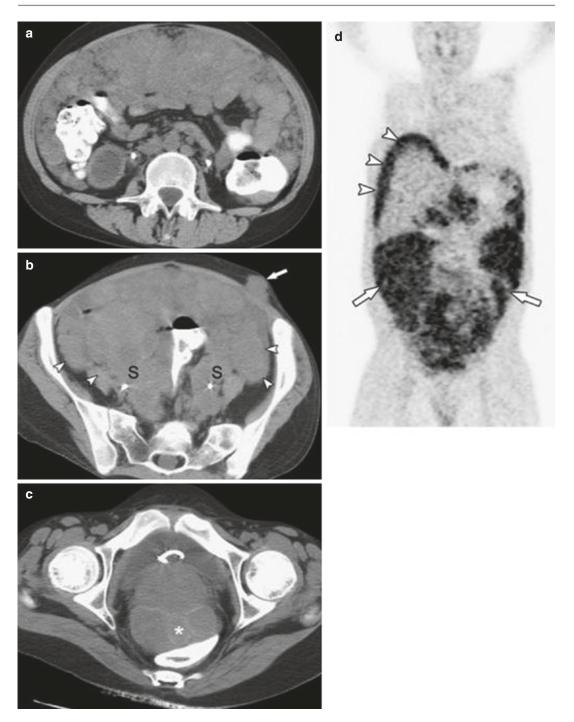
Desmoplastic round cell tumor in a 14-yearold boy. Axial (unenhanced) CT image (a) shows diffuse studding of the omentum and peritoneal surfaces by innumerable soft tissue masses. Axial image through the pelvis shows lobulated low attenuation masses (*arrow heads*) and a large retrovesical mass (*) displacing the rectum posteriorly (b, c). Note subcutaneous metastatic nodules in the lower left abdominal wall (*arrow*). Bilateral nephroureteral stents (s) were inserted to relieve obstructive hydronephrosis. Maximum intensity projection FDG PET (d) shows hypermetabolic peritoneal (*arrows*) and serosal disease (*arrow heads*) (SUV max 8.0) (Used with permission from Arora et al. [8]) low or isointense signal intensity relative to skeletal muscle. On T2-weighted images, inhomogeneous high signal intensity is typical. Sometimes small cysts or fluid–fluid levels as well as signs of hemorrhage or necrosis can be identified [152] (Fig. 18.36).
